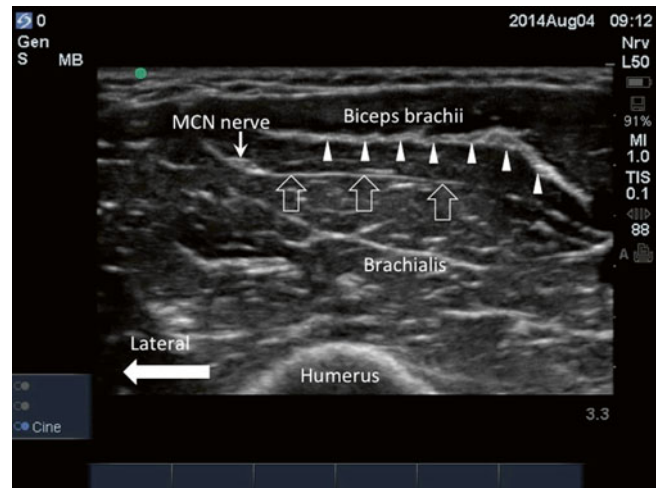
Sonogram of the cutaneous branch of musculospiral nerve. At distal one third of the arm, the nerve is consistently in the fascia plane between the biceps brachii and brachialis muscles (void arrows). The fascia plane between these two muscles can be difficult to be visualized because of anisotropy, and tilting the ultrasound until the plane is clearly seen is crucial. Some practitioners may mistake the tendon (arrowheads) of the biceps brachii as the fascia plane (Reproduced with permission from Philip Peng Educational Series)
